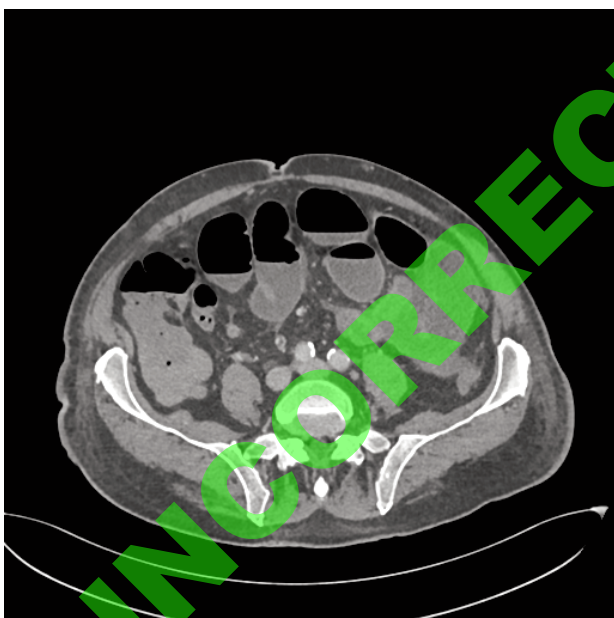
Imaging features of intestinal obstruction with distended small bowel loops and fluid levels revealed on an abdominal CT scan
